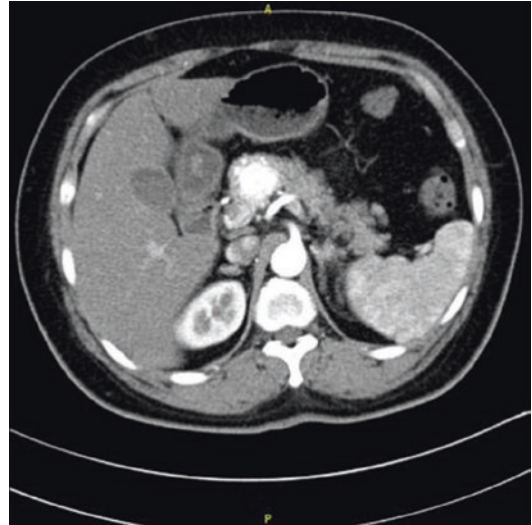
CT scan showed that an 18 mm × 13 mm nodule is seen at the neck of the pancreas
